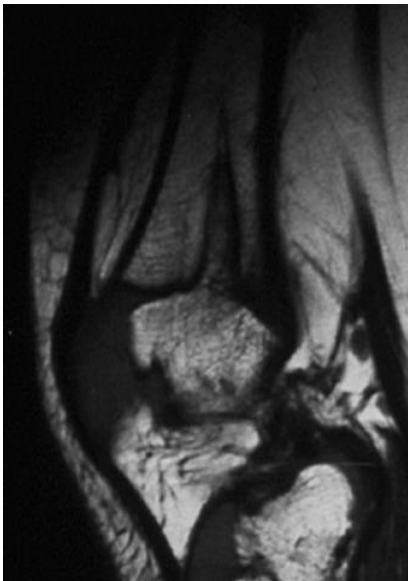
T1 sagittal MRI of the knee of a five-year-old boy with a central focal arrest with a tented appearance.
